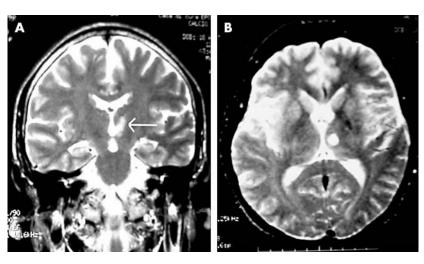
Magnetic resonance imaging of the brain. (A) Coronal view, T2 weighted (time of repetition/time of echo/excitations: 3800/120/2). (B) Axial view, T2 weighted (3800/120/2). A round hyperintense lesion is located in the paramedian portion of the left thalamus (A). The ischaemic lesion involves the medial thalamus (B) in the territory of the thalamo-perforating branches of the posterior cerebral artery.
